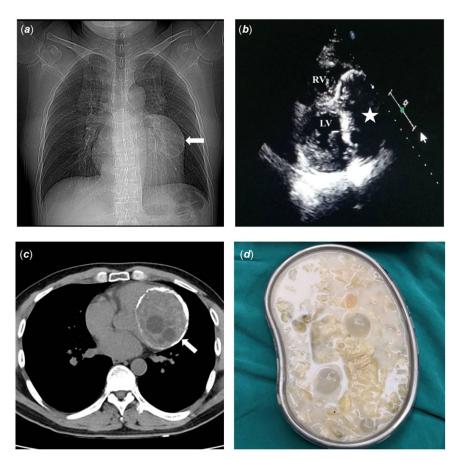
Chest radiograph showed a lump near the left upper hilum. Peripheral wall calcification could be seen (a); echocardiography confirmed the presence of a huge cyst in the pericardial cavity near the left and right ventricular walls. LV = left ventricle; RV = right ventricle (b); CT showed a pericardial hydatid cyst with peripheral wall calcification and multiple daughter cysts adjacent to the left ventricle (c); removed endocyst and daughter cysts (d).
